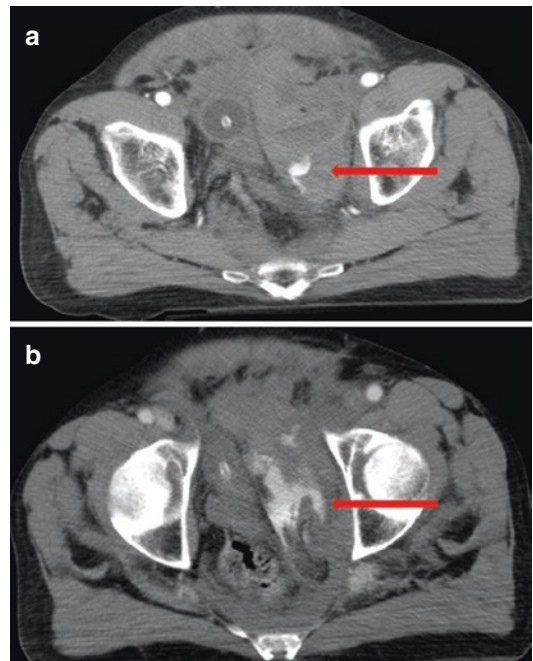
Acute arterial bleeding; axial CT image of the pelvis on arterial (a) and venous (b) phases. Extravascular hyperattenuating focus with attenuation similar to that of the iliac arteries in the extraperitoneal left pelvic space (arrow) (a) enlarging (arrow) in the following phase of acquisition (b)
